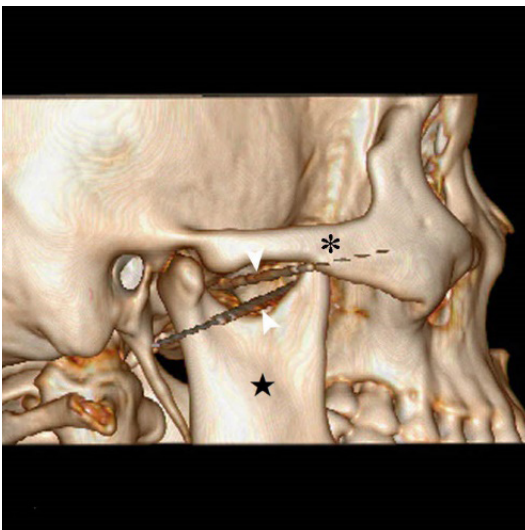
The 3D reconstruction CT showing the needle (White arrowhead) which with an infrazygomatic approach. * zygomatic; ★ Mandible.
